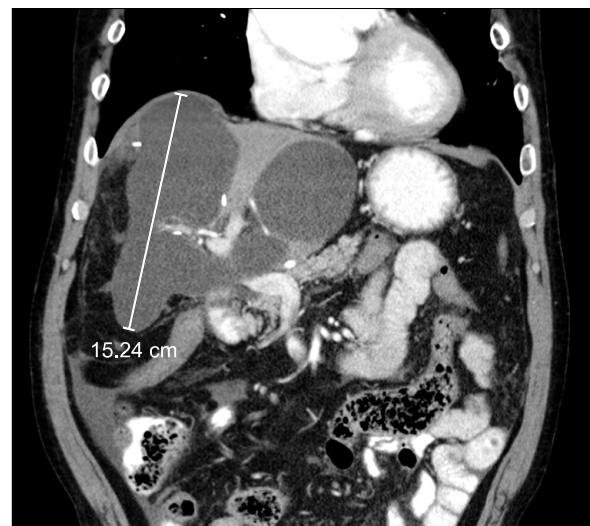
Postcontrast abdominal computed tomography shows a large intrahepatic fluid collection at the resected bed.
